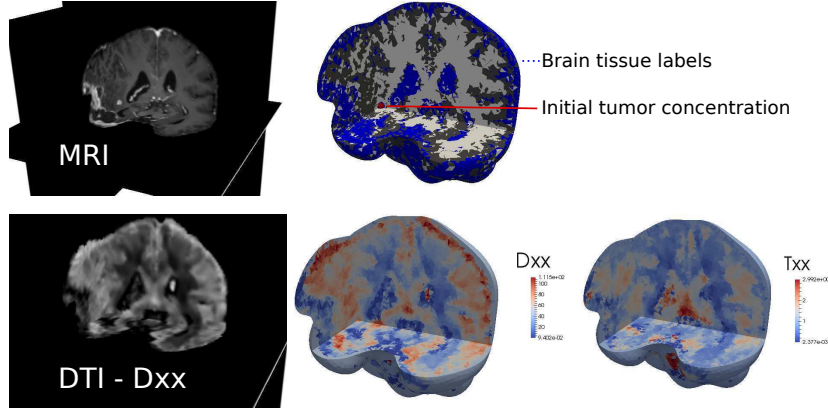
3D virtual reconstructions of the MRI (top) and DTI (bottom) data, with the corresponding computational meshes containing the labels of the brain tissues and the xx component of the tensors \mathbf{D} and \mathbf{T} . White matter, grey matter and CSF are highlighted in white, grey and blue colors respectively. The initial tumour distribution is also highlighted in brown color, as segmented from the T1-weighted MRI.
